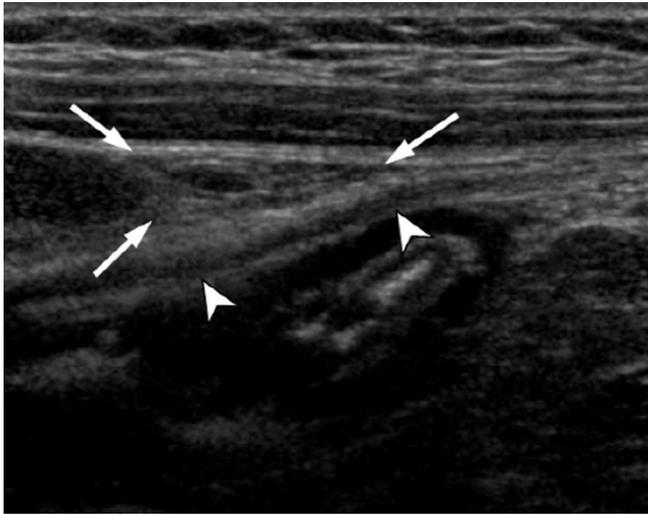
In a follow-up US after 14 days, the previous lesion was almost completely resolved. The falciform ligament (arrowheads) appeared normal and scanty amount of fatty appendage (arrows) were noted. US = ultrasound
